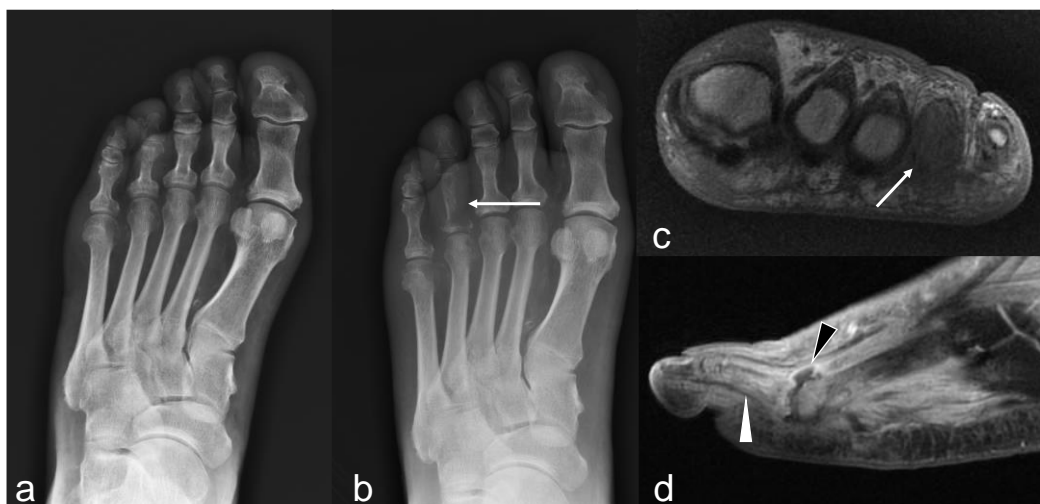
67-year-old man with 24-years history of diabetes. (a) Anteroposterior view of the foot does not show any relevant finding. (b) Corresponding anteroposterior view obtained 16 days later shows extensive bone destruction at the base of the fourth proximal phalanx (arrow). (c) Coronal T1-weighted MR image demonstrates diffuse bone marrow hypointensity of the fourth proximal phalanx (arrow). (d) Sagittal post-contrast T1-weighted fat-suppressed MR image shows capsular distension and synovial post-contrast enhancement of the fourth metatarsophalangeal joint indicative of infected/septic arthritis (black arrowhead). Thus, the diffuse post-contrast enhancement of the fourth proximal phalanx is consistent with acute osteomyelitis (white arrowhead).
